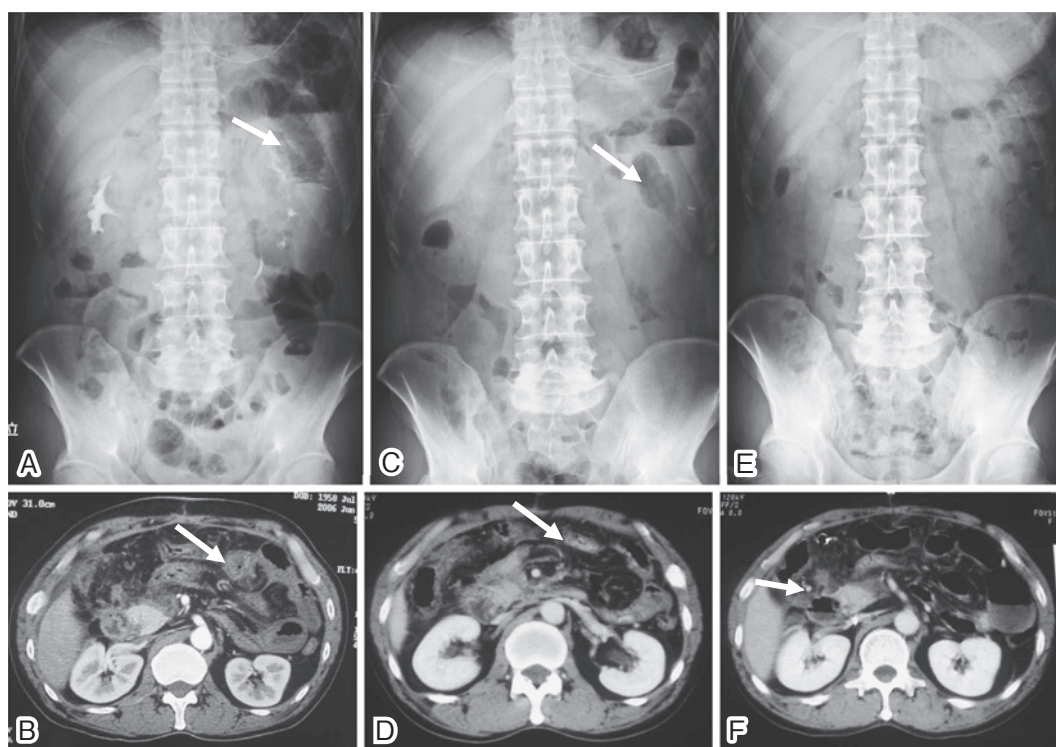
A: Abdominal X-ray film obtained on POD 11 showing dilated loops (arrow) of the proximal jejunum. B: A CT scan with contrast enhancement on POD 11 showing the thickened wall of the small bowel. C: An X-ray film obtained on POD 23 showing no marked change. D: A CT scan on POD 23 showing no decrease in the thickening of the wall of the small bowel. On POD 36, an X-ray film E: revealed no abnormal signs, and a CT scan F: showed the presence of collateral vessels (arrow).
